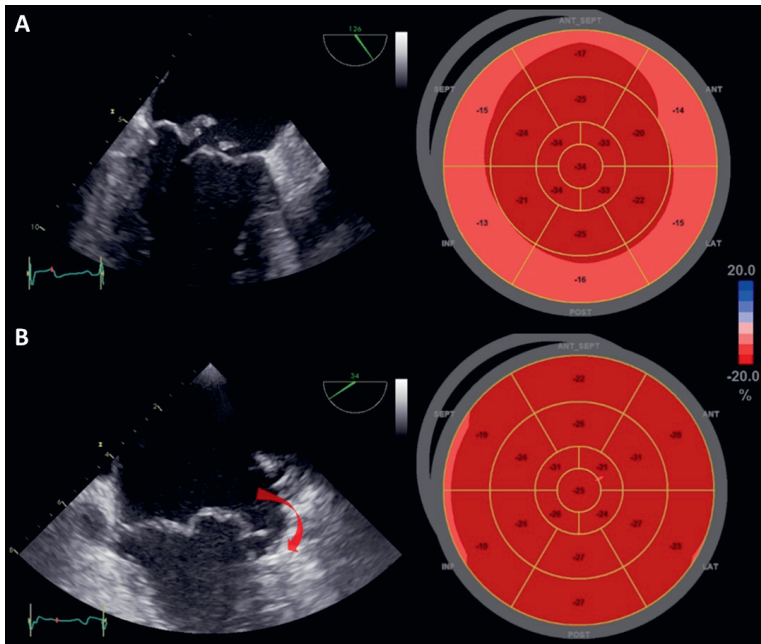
Per-level left ventricular longitudinal strain in fibroelastic deficiency and Barlow's disease. Transesophageal echocardiographic view of fibroelastic deficiency (FED) patient (A) and Barlow's disease patient (B) and corresponding bulls' eye plots with longitudinal strain values per level. Note that in the FED patient, the basal level shows more impaired myocardial longitudinal strain values as compared with the Barlow's disease patient. The enhanced myocardial longitudinal shortening of the basal level in Barlow's disease patient may contribute further to the incompetence of the mitral valve by pulling down the insertion of the mitral leaflet (arrow).
